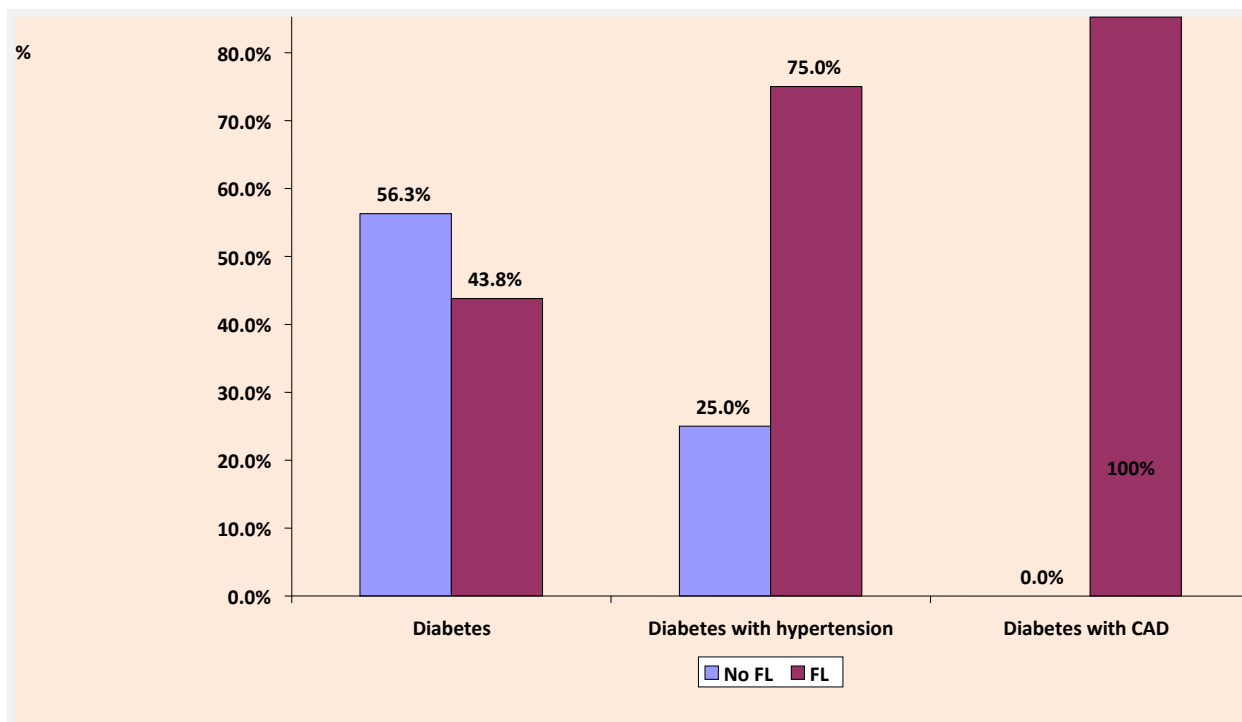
The overall prevalence of NAFLD in diabetes, diabetes with hypertension and diabetes with coronary artery disease using ultrasound.
